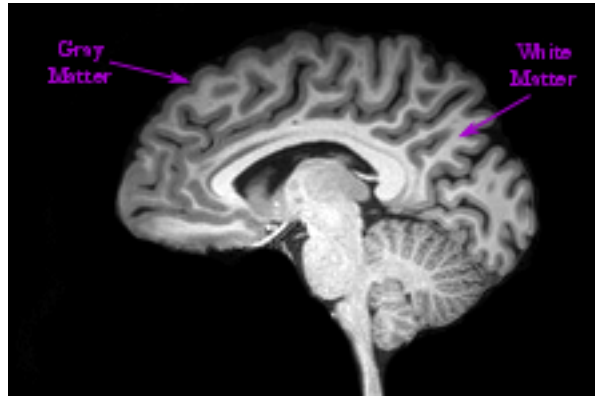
Sagittal view of the brain from a T1-weighted MRI. The gray matter of the cerebral cortex appears gray in this type of image whereas the underlying fat-like white matter appears bright white due to the abundance of myelin sheaths that surround nerve pathways.
